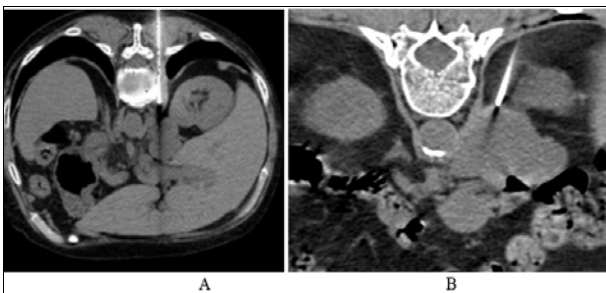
a, b: Depicting CT guided biopsy of retroperitoneal lymph nodes in prone posture.
